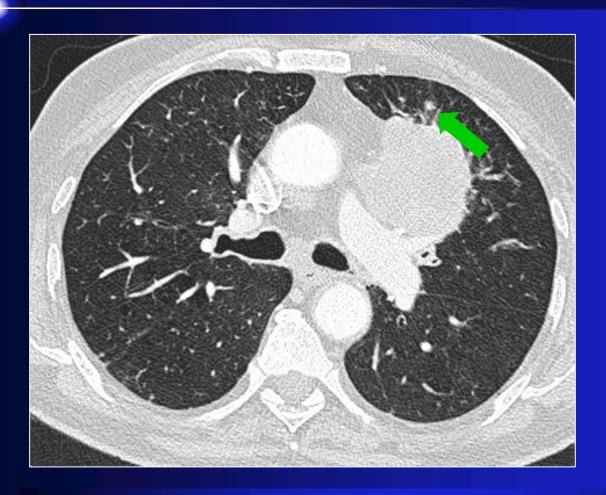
IMAGE FROM: Nair A et al. Revisions to the TNM staging of non-small cell lung cancer: rationale, clinicoradiologic implications, and persistent limitations *Radiographics* 2011;31:215-238
